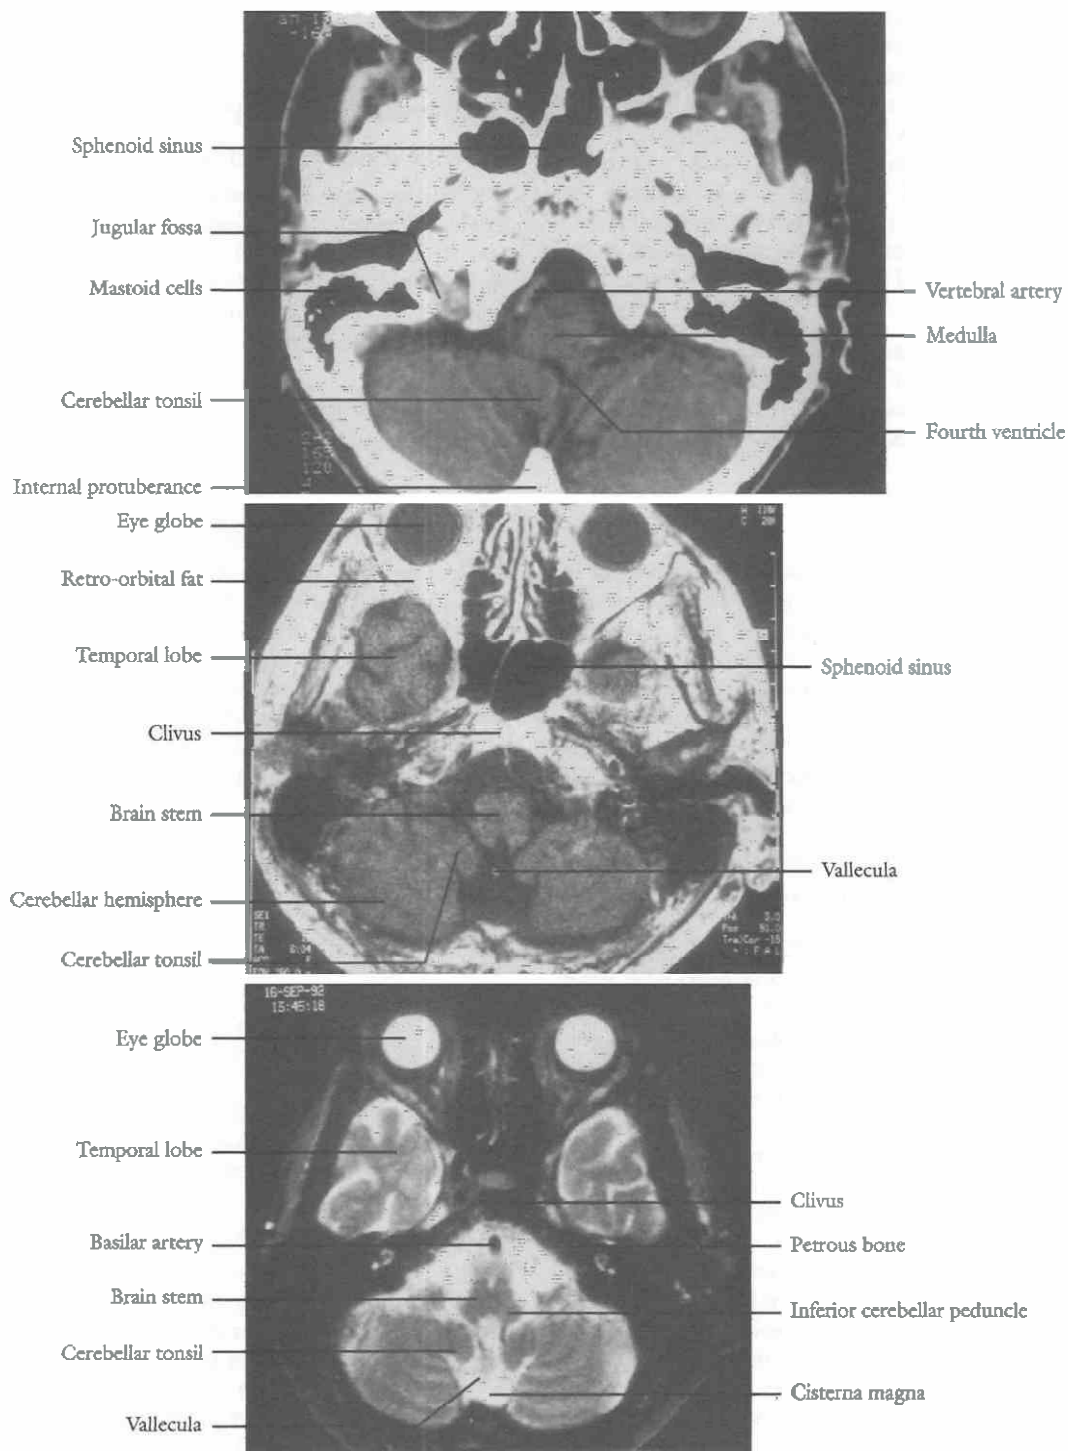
Top*, Enhanced axial CT scan above the foramen magnum. *Center*, Axial T1 MRI scan above the foramen magnum. *Bottom*, Axial T2 MRI scan above the foramen magnum.
